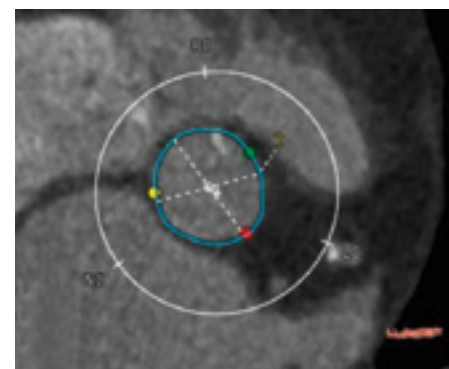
CT scan measurement of the aortic annulus
